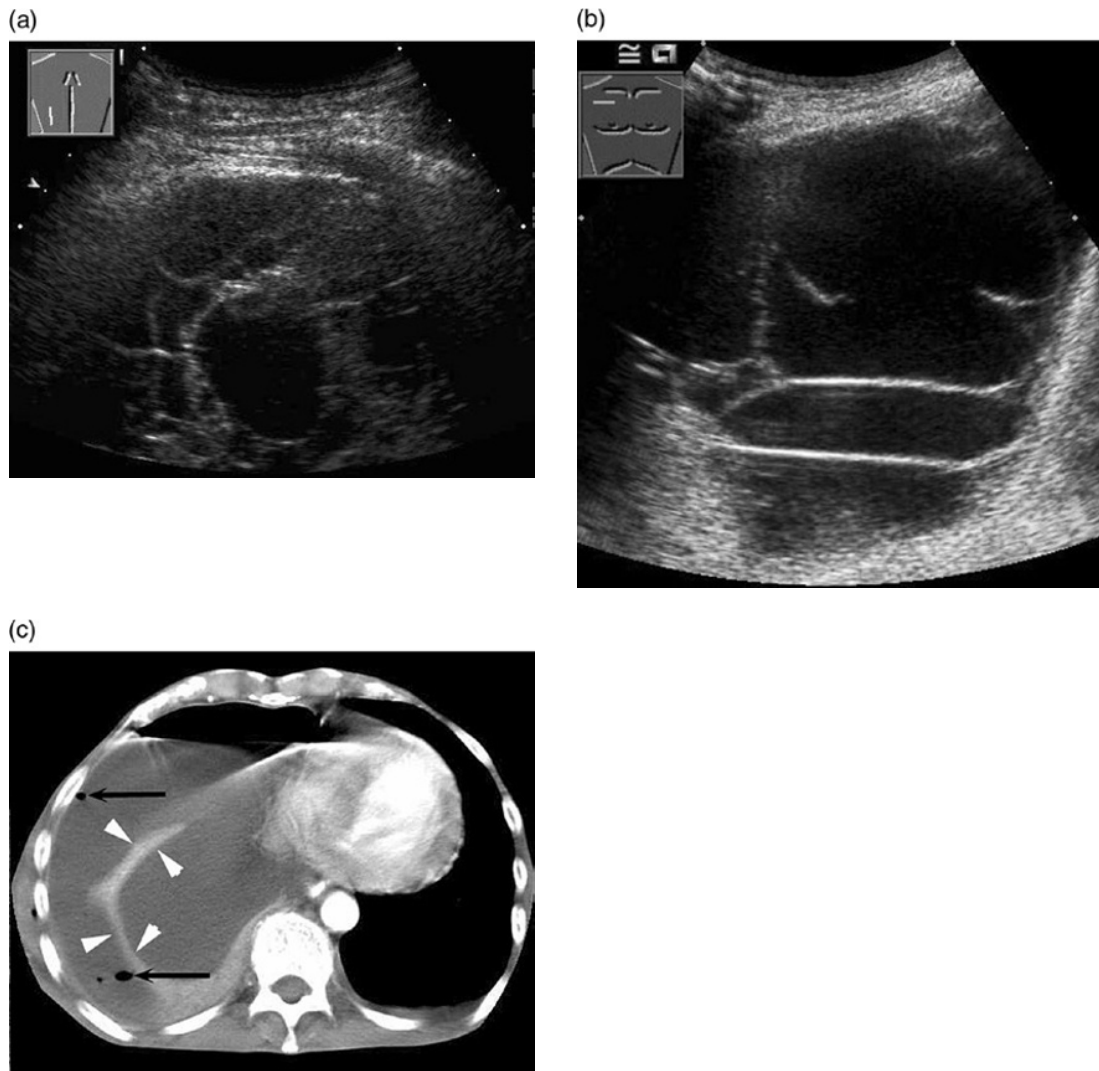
(a,b) Two complex septated effusions. The CT from panel (b) is shown in panel (c) with atelectatic lung (white arrowheads) and pockets of gas (black arrows) that suggest the presence of septations because they are not floating. As can be seen, ultrasound identifies septations with greater clarity than CT, and real-time ultrasound allows for drainage with directed access to multiple cavities.
